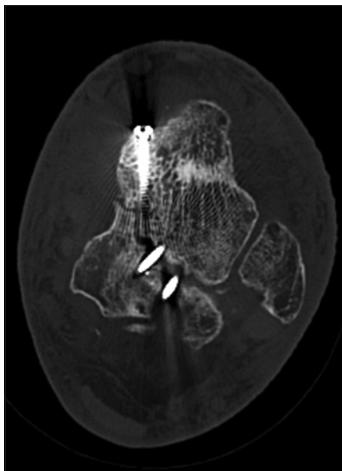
This axial computed tomography image of the talus demonstrates a clear fracture line despite the previous fixation. The posterolateral fragment is distinct and separate
